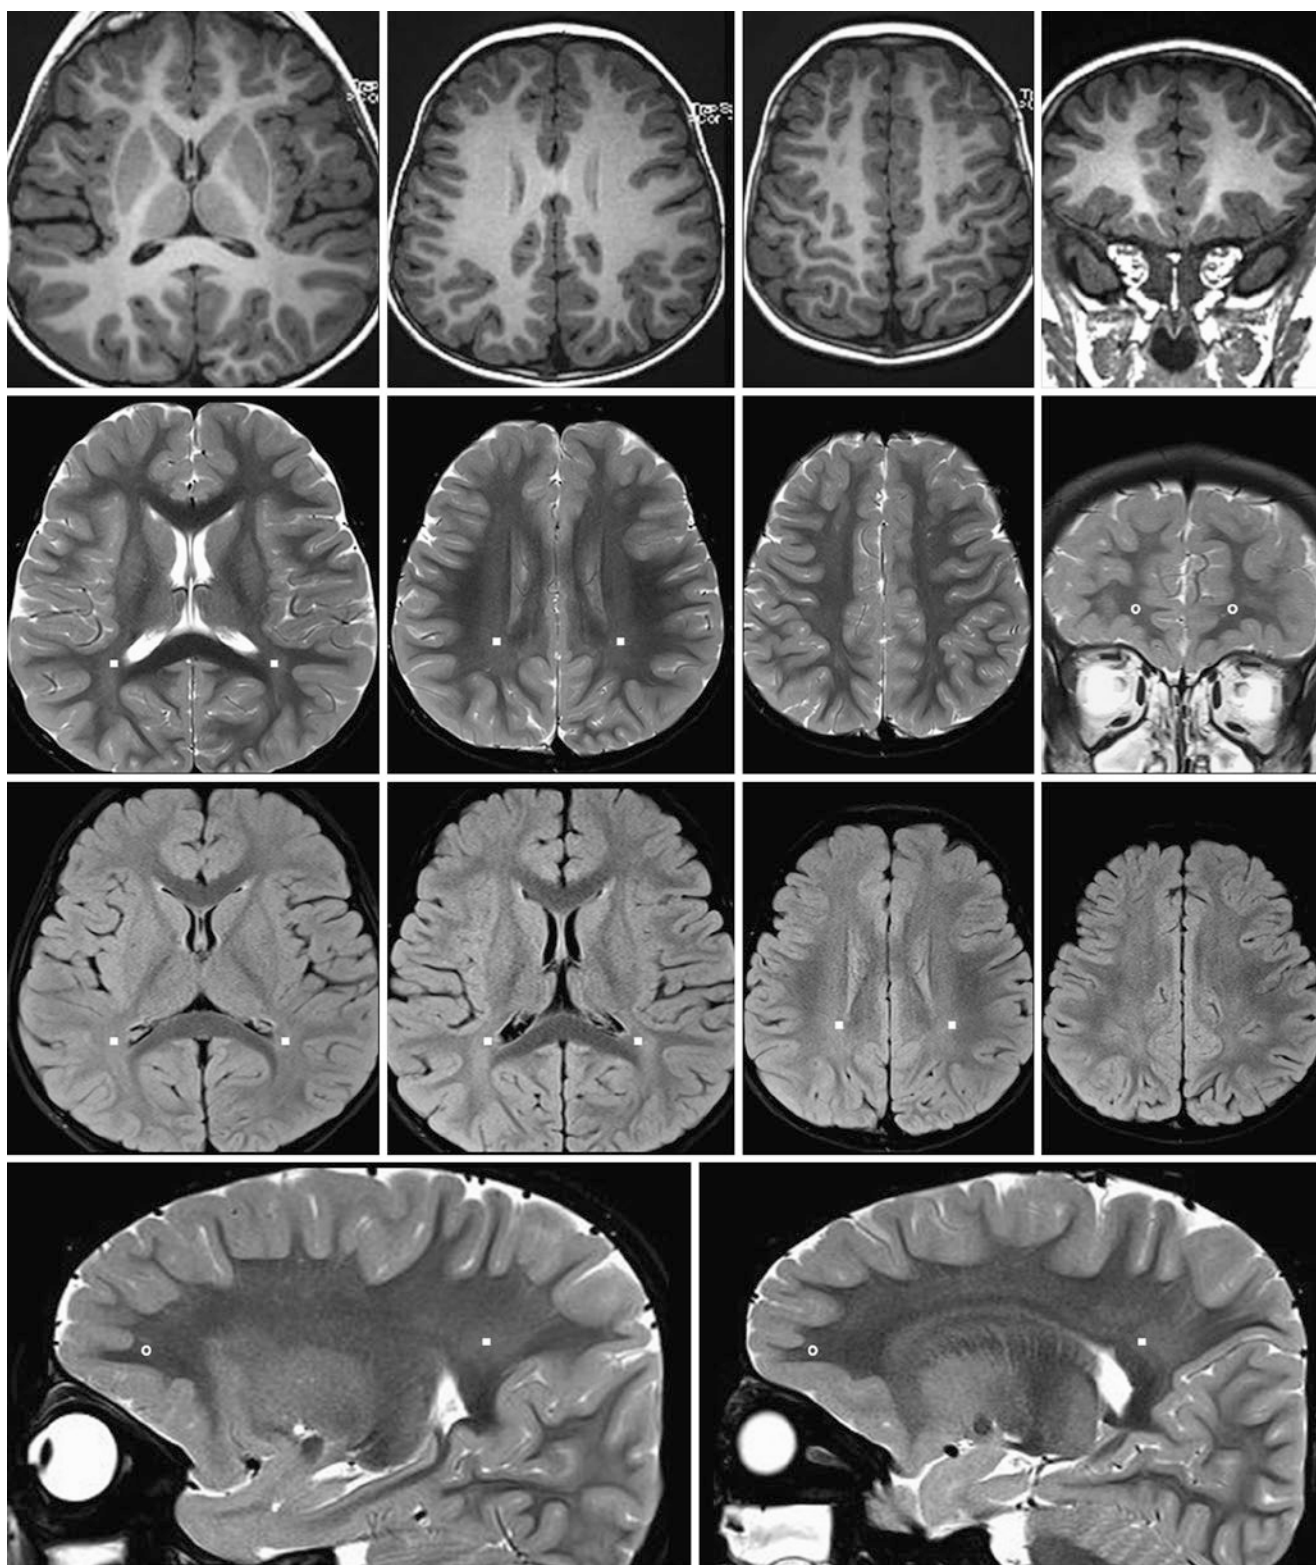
A 2.75-year-old with “skin spots” had a normal 3T MRI. The child’s neurodevelopment was normal. *Top row:* On axial GE T1WIs (left three images), the myelination pattern appears normal, as in an adult. The residual terminal zones are hardly visible. A coronal GE T1WI anteriorly (right) shows normal OFWM. *Second row:* On axial SE T2WIs of the left (left) and right (right) sides, note the mild, residual PTWM terminal zones (squares). A coronal SE T2WI anteriorly (right) shows normal
